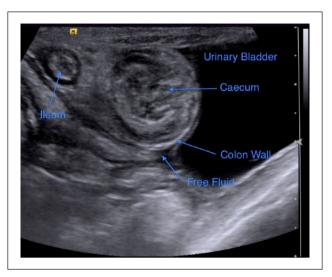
Transverse ultrasound image of the caecocolic intussusception. The caecum is contained within the boundaries of the colonic wall
